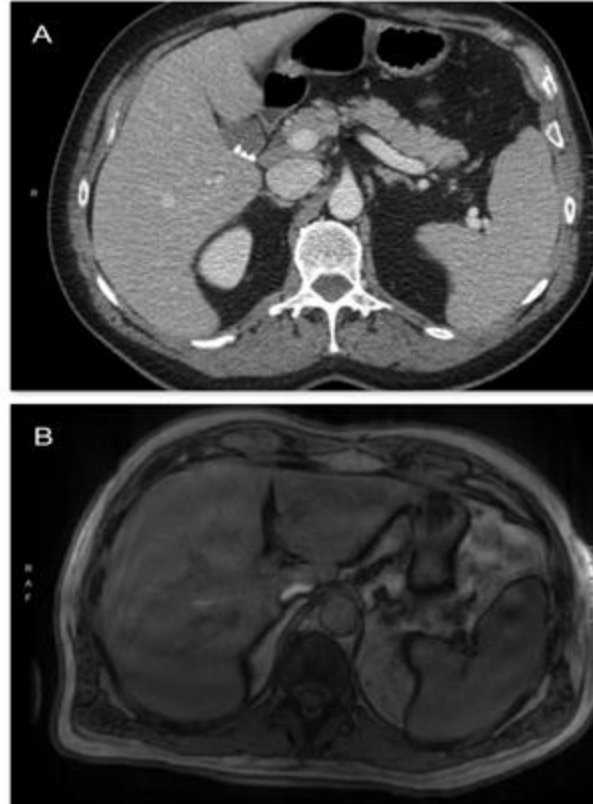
Computed Tomography (CT) of the abdomen and pelvis with hepatosplenomegaly and cholelithiasis.
